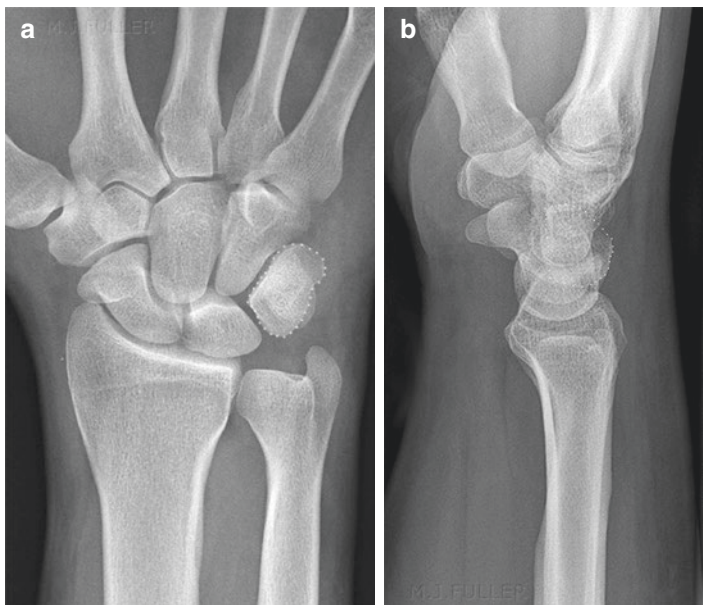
Triquetrum X-ray: (a) PA view, (b) lateral view. (a, b: Used with permission from <http://www.wikiradiography.net/page/Triquetral+Fractures>)
